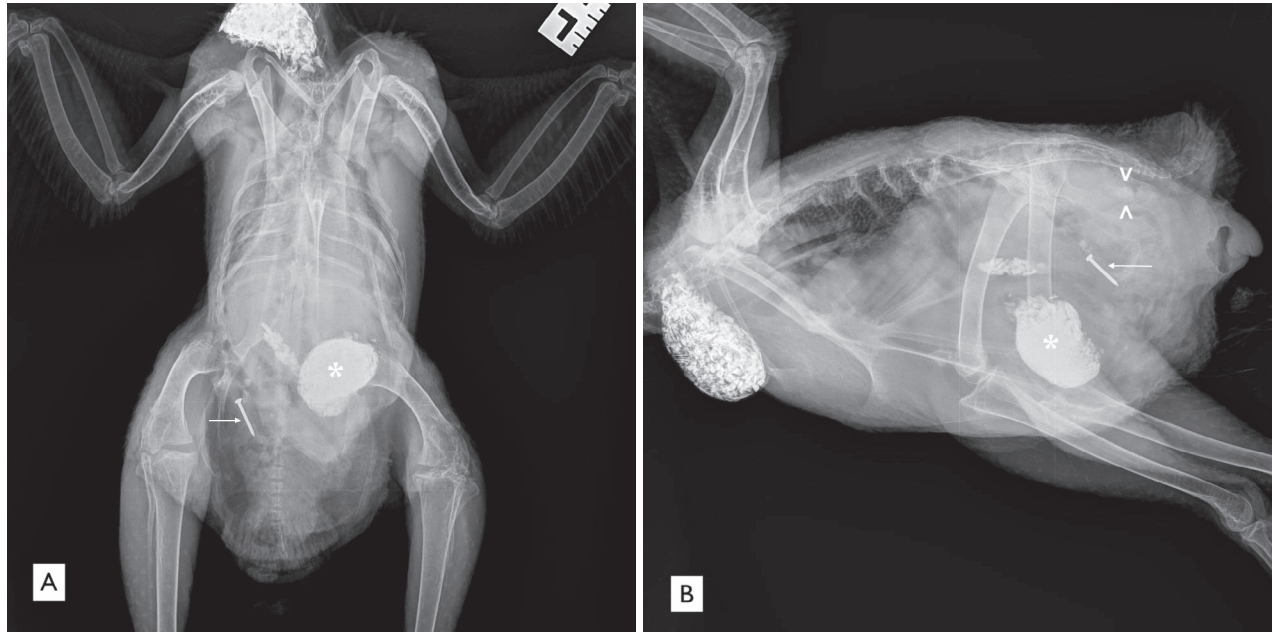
Ventrodorsal (A) and lateral (B) radiographic views of the coelomic cavity of an adult domestic hen that presented with intermittent lameness of the left limb. A full abdomen with loss of abdominal detail and a large amount of mineral-attenuating material in the ventriculus (asterisk) and crop are noted. A nail is noted in the right caudal aspect of the coelomic cavity (arrow). At least 1 rounded structure of soft tissue to mineral opacity is noted caudal to the kidneys in the lateral view (arrowheads).
